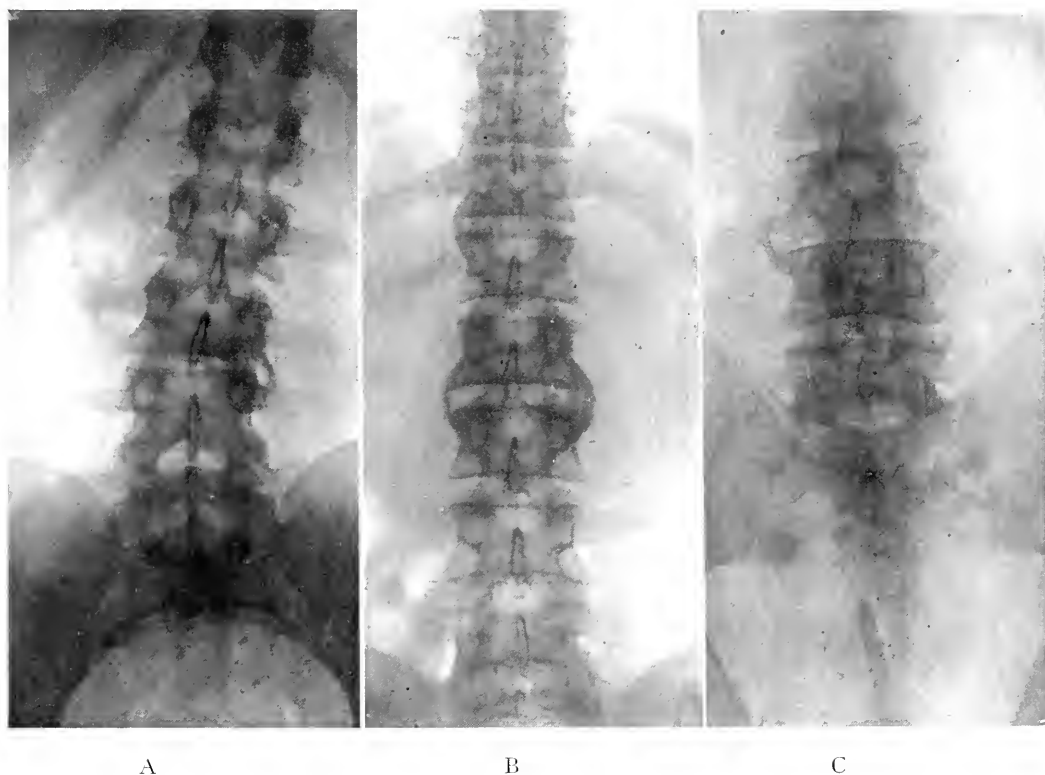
DEEP OSSEOUS RADIOGRAPHY FOR DISEASE.
